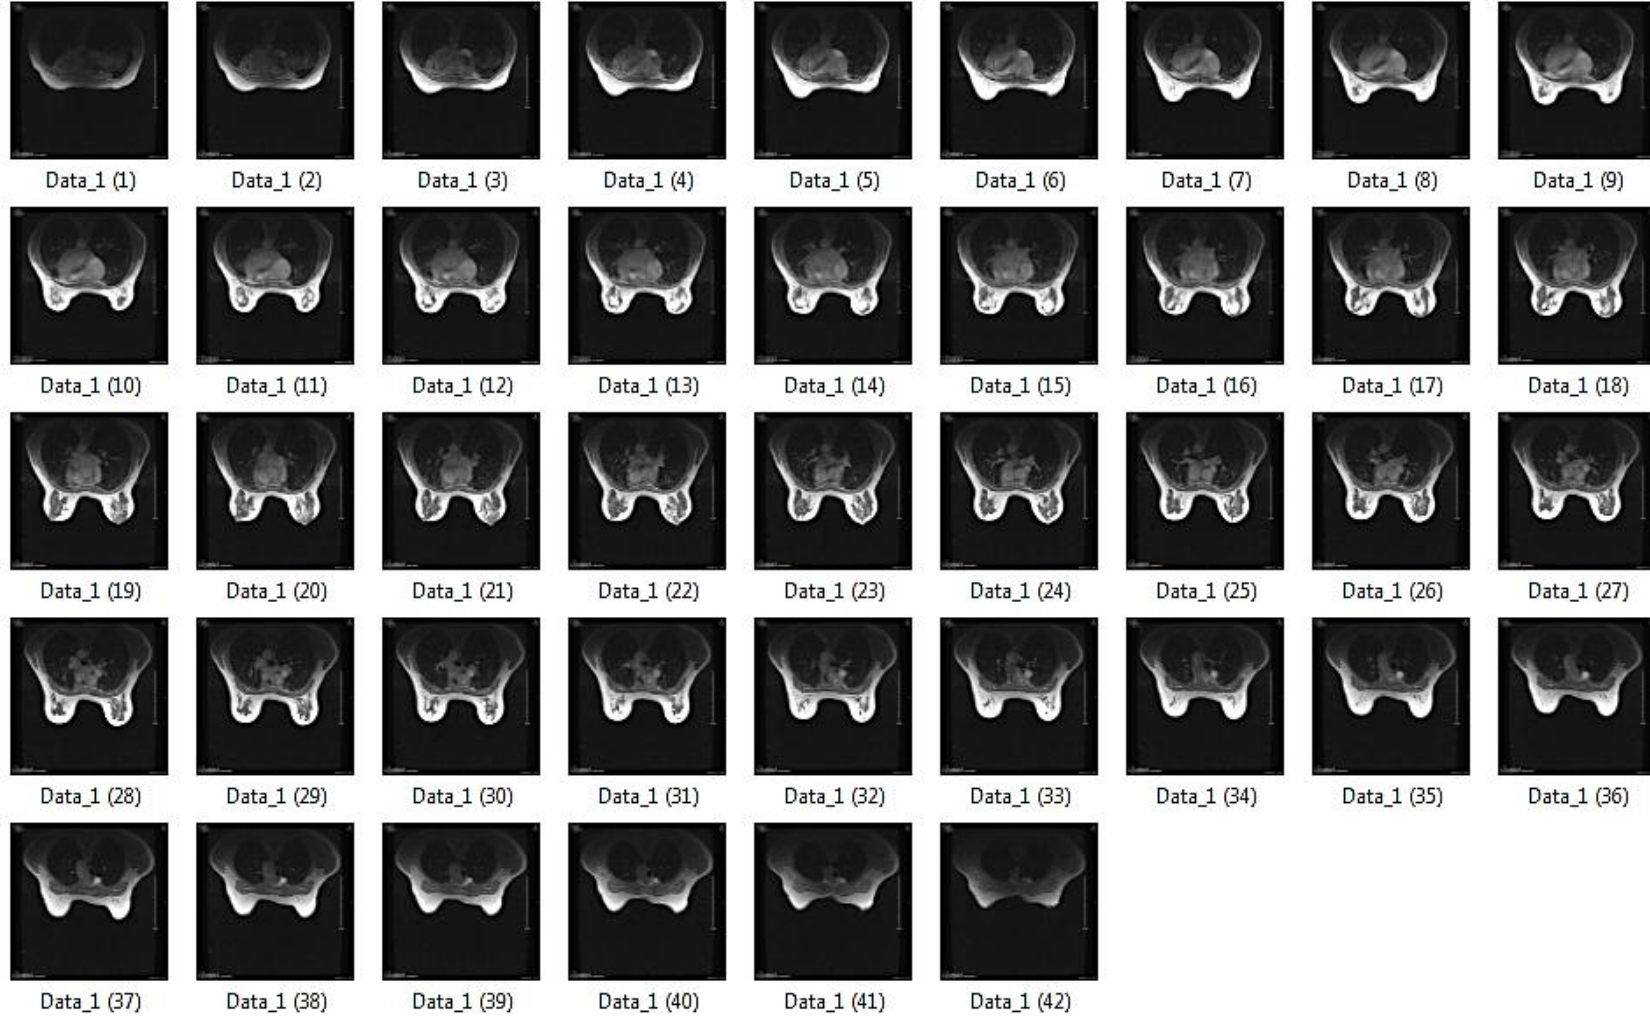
An example of MRI data which consists of 42 slices of an anonymous patient in prone position.
